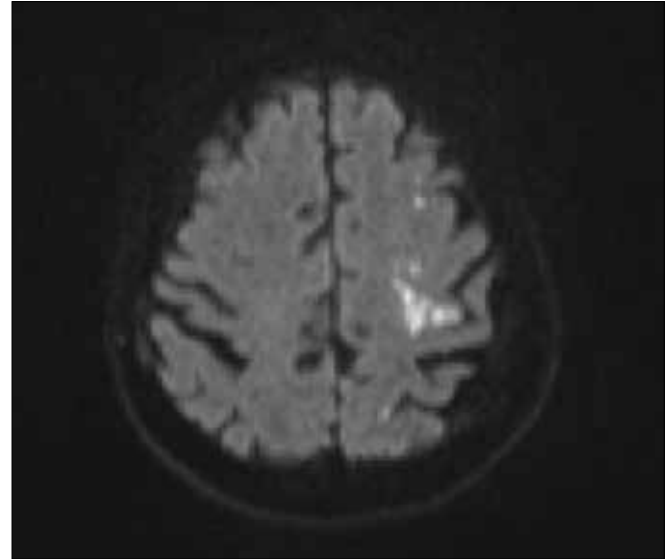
CT Head showing acute infarct in the left superior frontal gyrus.
